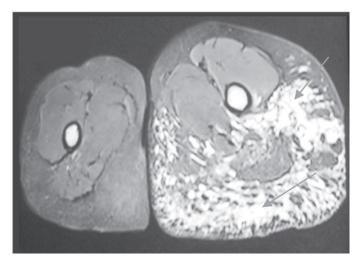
MRI pelvis and thighs - Extensive vascular malformation (arrows)
